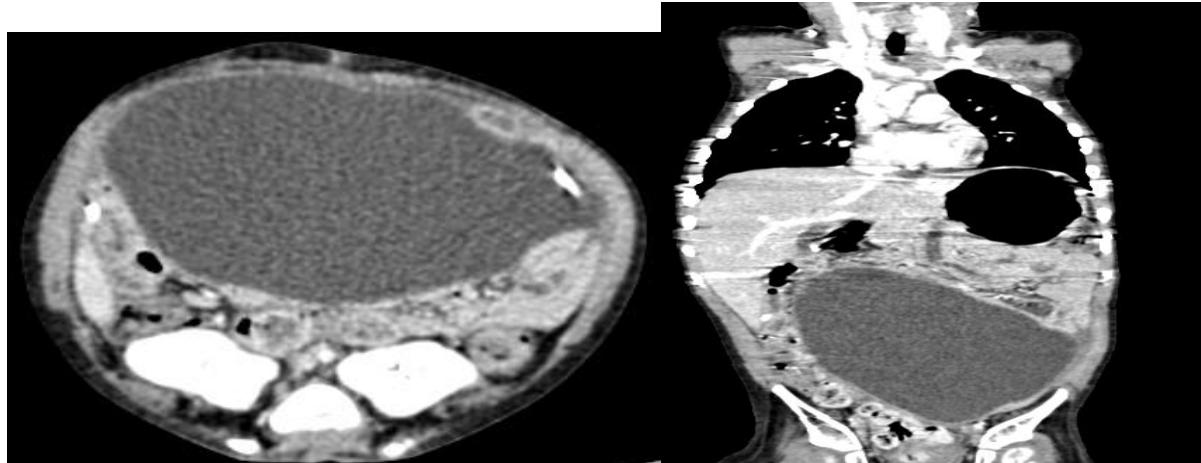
(a, b): Abdominal CT scan with injection of contrast product in axial section with coronal reconstruction showing a voluminous oval abdomino-pelvic mass well limited of homogeneous to fine fluid enhanced after injection of contrast product, coming into contact with the distal end of the ventriculo bypass drain -peritoneal. This mass comes into contact with the anterior abdominal wall in front, pushes back the digestive structures, the transverse colon at the top and the bladder dome at the bottom.
